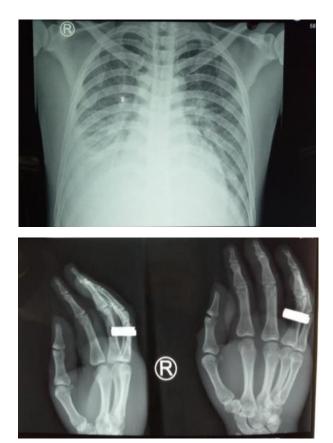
Thorax X-ray (2A) and Manus Dextra (2B)
